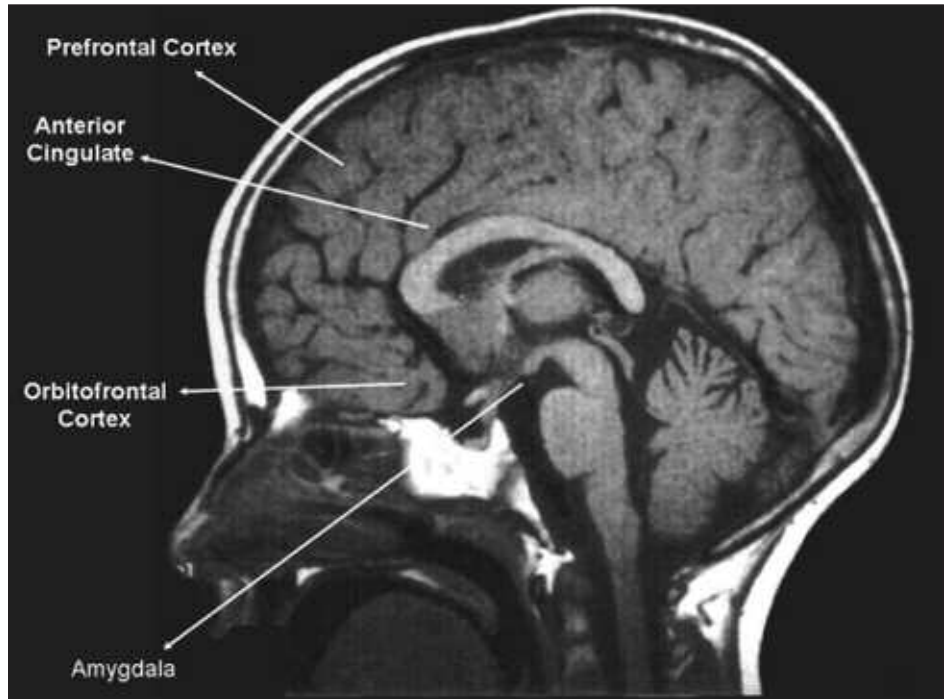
MRI Demonstrating Neuroanatomic Regions Associated with Addiction.
